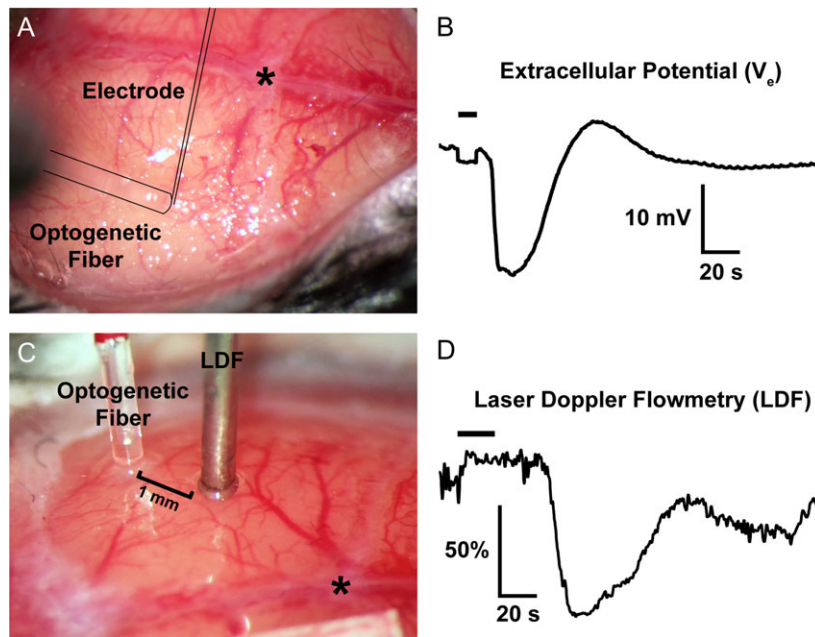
Representative optogenetic SDs through the intact skull. (A,B) The optical fiber, out of focus in this image, is outlined, as is the glass micropipette inserted through a $<100\text{-}\mu\text{m}$ burr hole next to the optical fiber to record the extracellular slow potential shifts (V_e) in the right whisker barrel cortex. (C,D) A laser Doppler probe (LDF) away from the optical fiber non-invasively detects the propagating blood flow changes associated with an SD that was optogenetically induced in left visual cortex. SD induction and subsequent propagating blood flow changes are also shown in the Supplemental Video at 20x speed. Horizontal bars on the tracings show illumination period. *, bregma.
